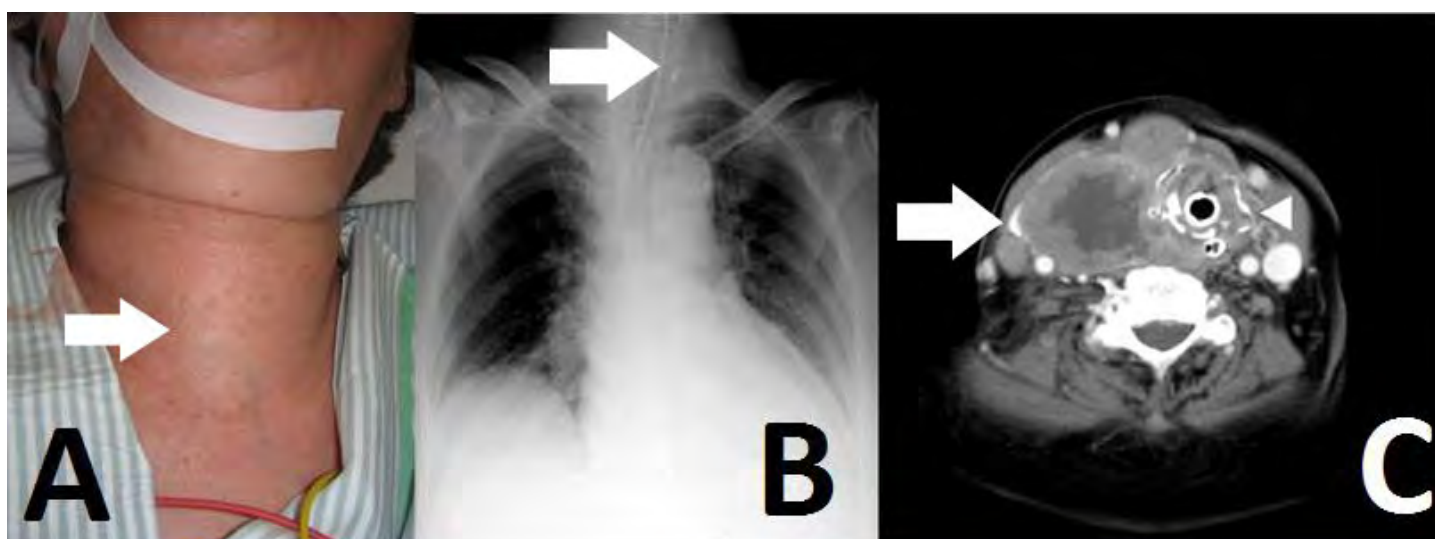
(A) Image showing swelling of the neck in our patient (arrow). (B) Chest radiograph after intubation showing a shift of the trachea to the left (arrow). (C) Contrast computed tomography image showing the thyroid tumor superior to the right lobe (arrow) and tumor invasion into the trachea at the height of the cricoid cartilage (arrow head).
